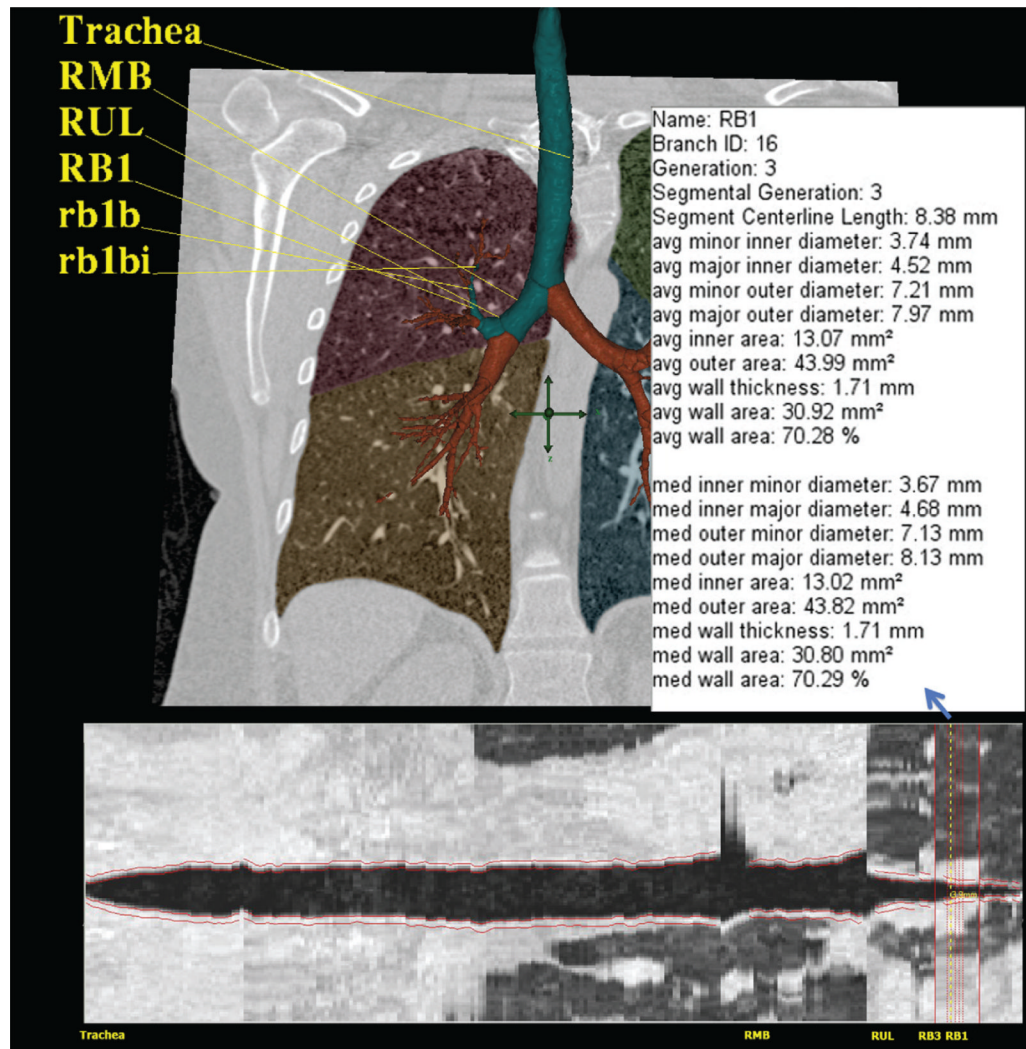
Three-dimensional and cross-sectional quantitative CT of the airway and lungs in asthma
